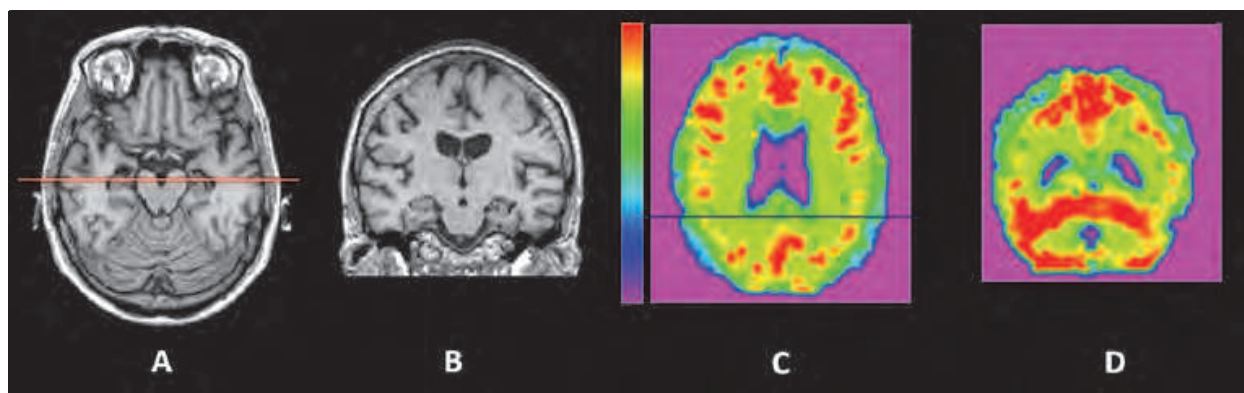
Brain MRI (Magnetic Resonance Imaging) and perfusion SPECT (Single Photon Emission Computed Tomography) images of a patient with AD in early stage examined in our institution (female, age= 66 years, Mini Mental State Examination (MMSE)=22); all images are oriented in the radiological convention. A) Axial view of high resolution MRI image (T1) showing brain atrophy, particularly in the hippocampus bilaterally; B) Coronal slice at the level of the red line show in the axial view; C) ^{99m}Tc -ECD SPECT image using a double-head system and corrected for partial volume effect (corrected for atrophy), showing regional hypoperfusion in the parietal regions, particularly in the angular gyrus bilaterally; and D) Coronal slice at the level of the blue line show in the axial view C. For comparison see figure 2 with similar images of a clinically healthy subject.
